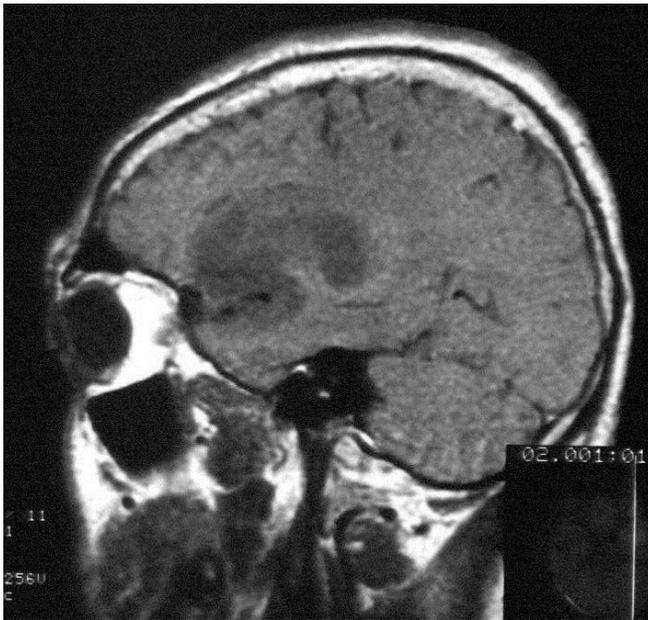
Arachnoid cyst. MRI demonstrates a sharply-marginated non-enhancing hypointense lesion in the left insular cistern.
